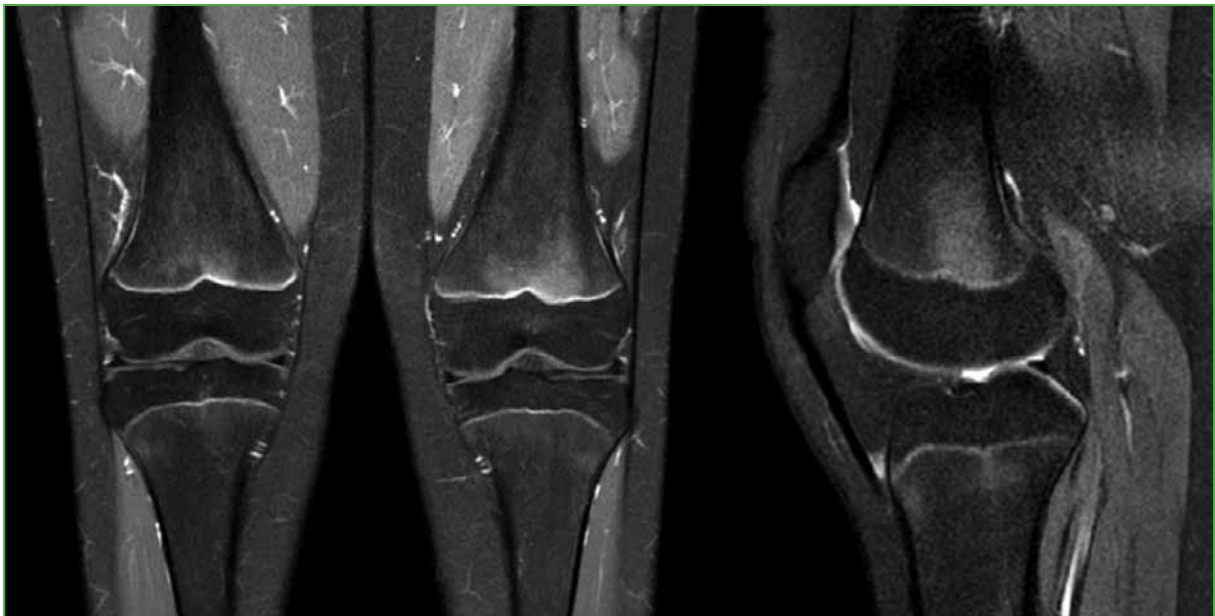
MRI of the knee. Central and symmetric bone marrow edema in the bilateral distal femoral metaphysis, intensified in the left knee.
